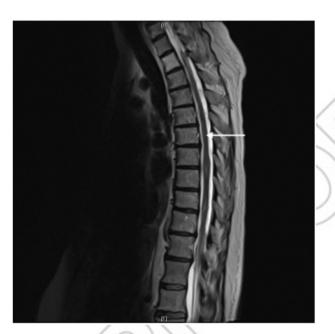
MRI spinal cord, sagittal T2: spinal meningeal involvement by sarcoidosis manifesting as linear leptomeningeal enhancement along the thoracic spinal cord (arrow). Courtesy of Dr Fang Zhu, Chicago.
